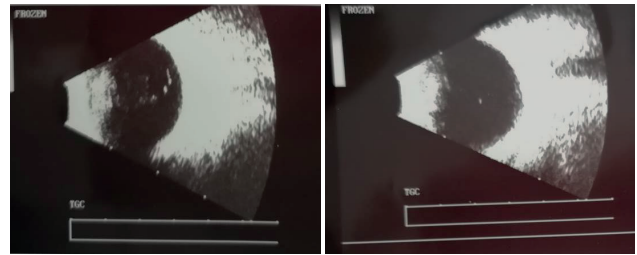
Ultrasound of right and left eye with vitreous inflammatory reaction
